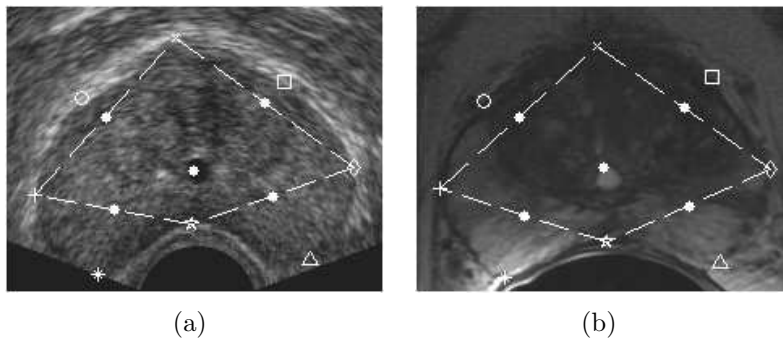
Point correspondences on TRUS and MR images. Correspondences inside the prostate are shown by white ‘•’s. The dashed line signifies that the white ‘•’ falling on the line is the mid-point of the same joining the correspondences established on the contour.
